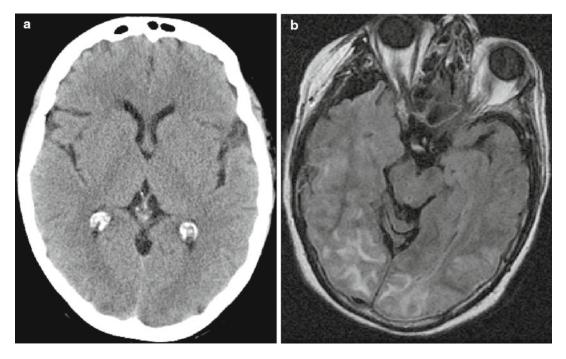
Posterior reversible leukoencephalopathy syndrome (PRES). Axial unenhanced CT (a) shows subtle loss of differentiation between *gray and white matter*
